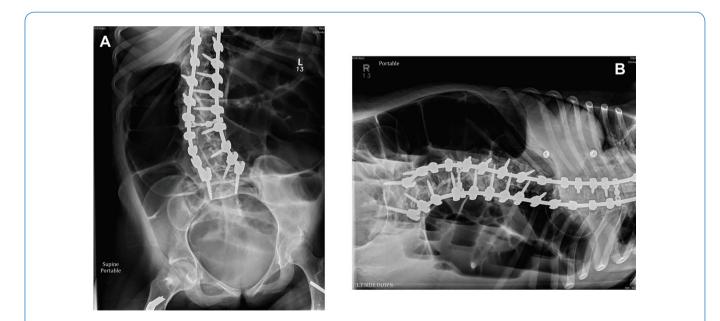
a) AP and; b) lateral abdomen radiographs showing distended bowel loops with air-fluid levels and a small amount of free intraperitoneal air.
